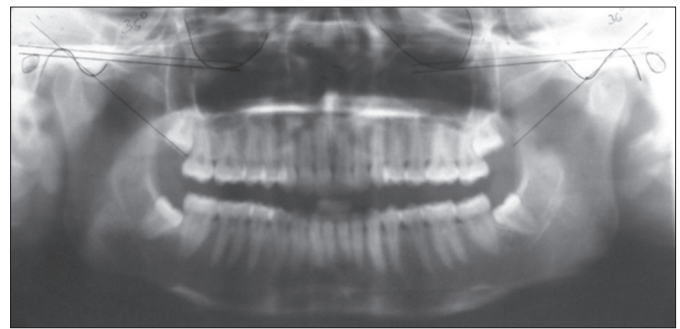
Tracing of condylar guidance angle on panoramic radiograph in dentate patients.
